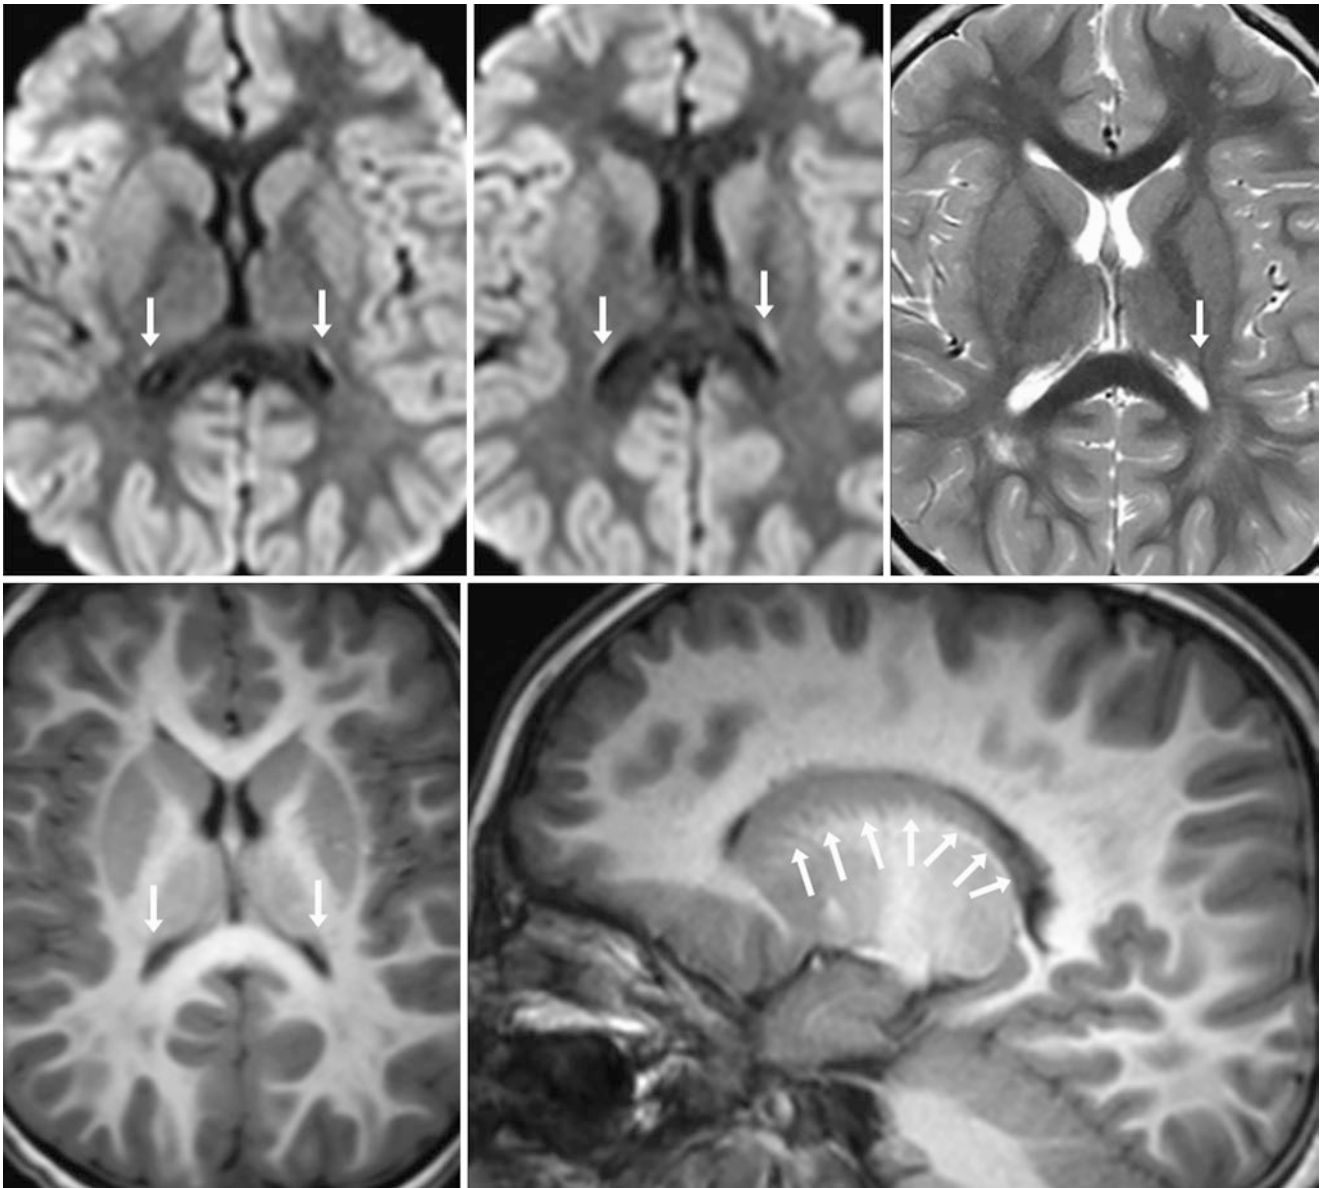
A 3 year old with febrile seizures; on a negative 3 T MRI, axial DWIs (*top left and middle*) showed mild, linear bright signal within what was confirmed to be the caudate tail (*arrows*) on T2WI (*top right*). This was seen as well on three-dimensional T1WI that was
